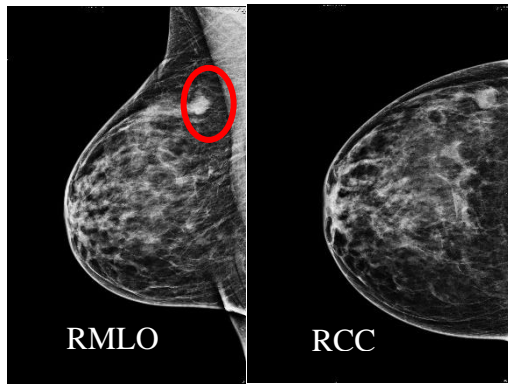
16 X-ray images of Patient 0700, right breast.
